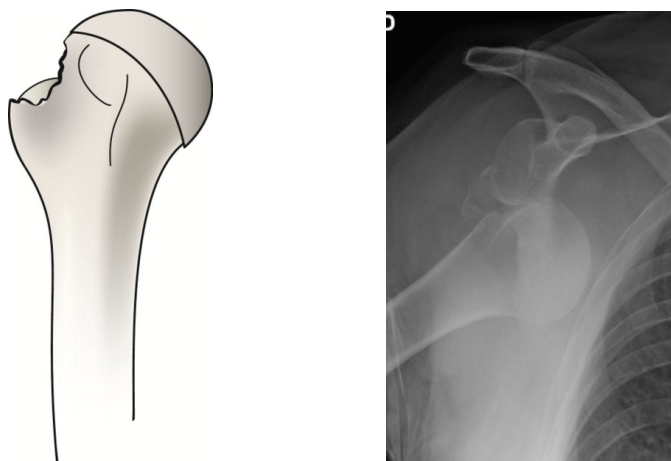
/Radiograph 3: An artist's rendition and anteroposterior radiograph of the typical Depression-type fracture. The entire greater tuberosity is impacted into the humeral head and individual fragments are displaced inferiorly.
